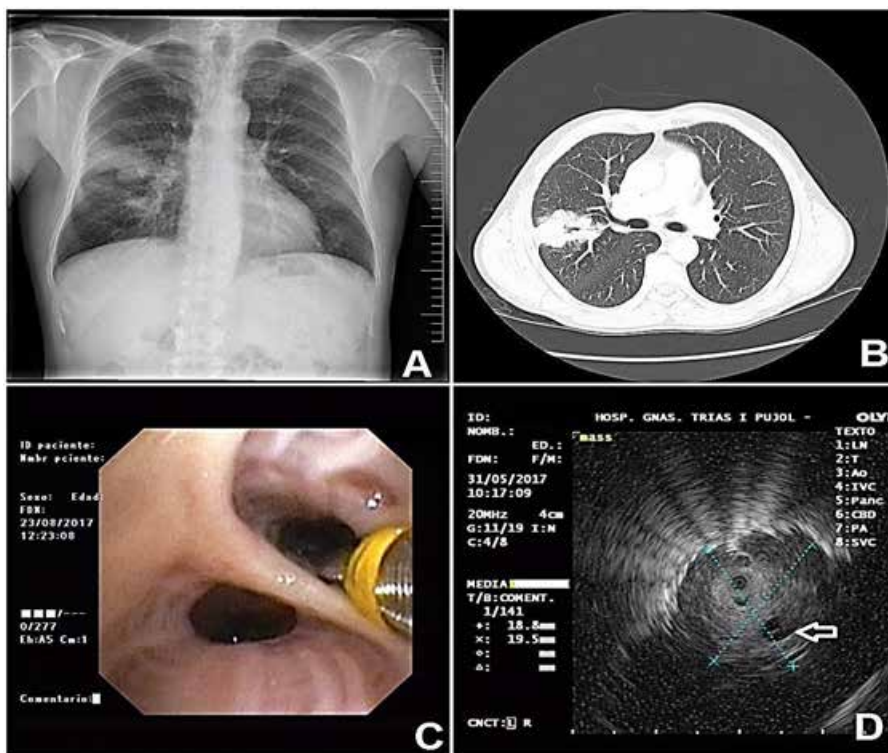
(Case 2): A) Chest X-ray showing a mass in right lung. B) Thoracic CT showing the mass in the right middle lobe. C) Radial probe EBUS operating to visualize the mass. D) Ultrasound image of the mass showing a nearby vessel (arrow) with high risk of severe bleeding if TBCB was performed.
